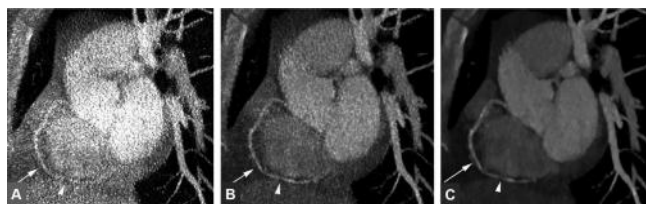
Images of coronary computed tomography angiography of the right coronary artery reconstructed with (A) filtered back projection, (B) hybrid iterative reconstruction (iDose⁴), and (C) iterative model based reconstruction. The white arrow points at the right coronary artery, and the white arrowhead points at a noncalcified plaque. The images demonstrate noise reduction of iterative reconstruction when compared to filtered back projection. Figure reproduced with permission from ref 61.
